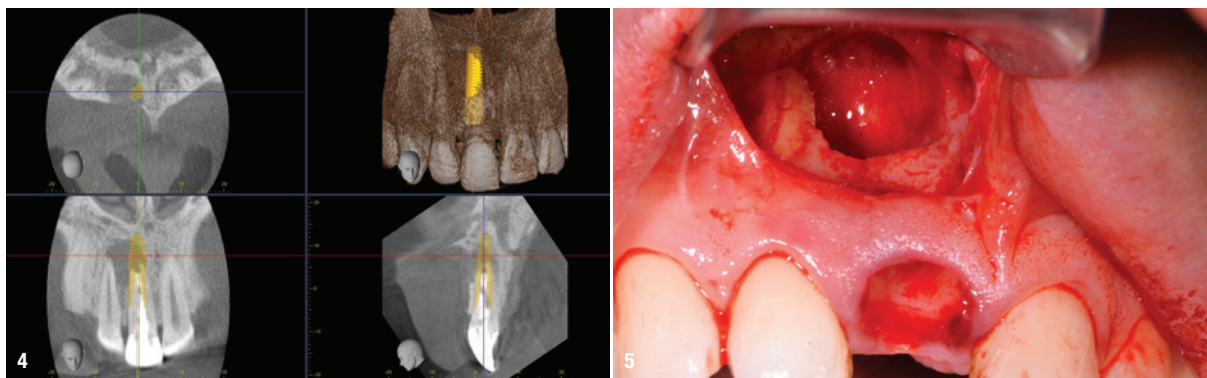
CBCT scan showing the planned implant placement. – Fig. 5: Extraction socket with the infra-bony cyst cavity exposed.
